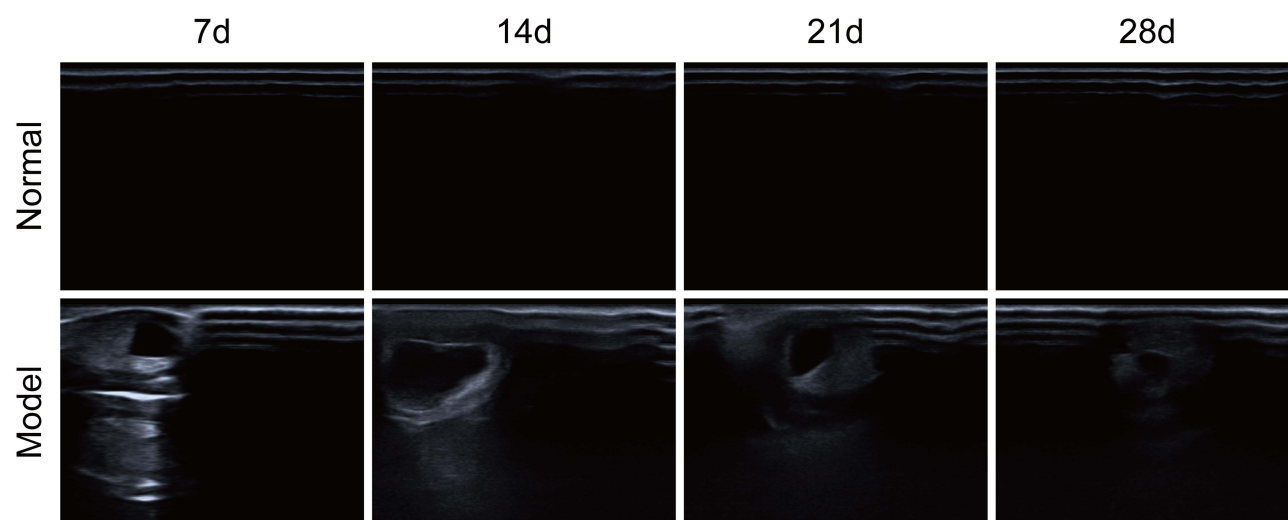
B-ultrasound morphology of the mammary glands in the model group at 7, 14, 21, and 28 days after modeling. At 7 days after modeling, obvious irregular hypoechoic areas were visible, with anechoic areas inside, and strong echo bands with posterior acoustic shadowing or attenuation were visible below; at 14 days, the hypoechoic areas shrank, and the internal anechoic dark fluid areas expanded; at 21 days, both the hypoechoic and anechoic areas shrank; at 28 days, the hypoechoic areas were significantly reduced with blurred boundaries, and a small amount of residual anechoic areas were visible.
